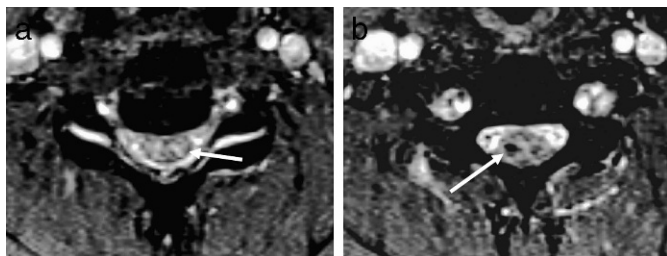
Cord contusion and hemorrhage. (a) Axial T2-weighted image in a different patient showing increased signal consistent with cord contusion (arrow). (b) Additional T2-weighted image images more inferiorly show signal dropout consistent with areas of cord hemorrhage (arrow).
